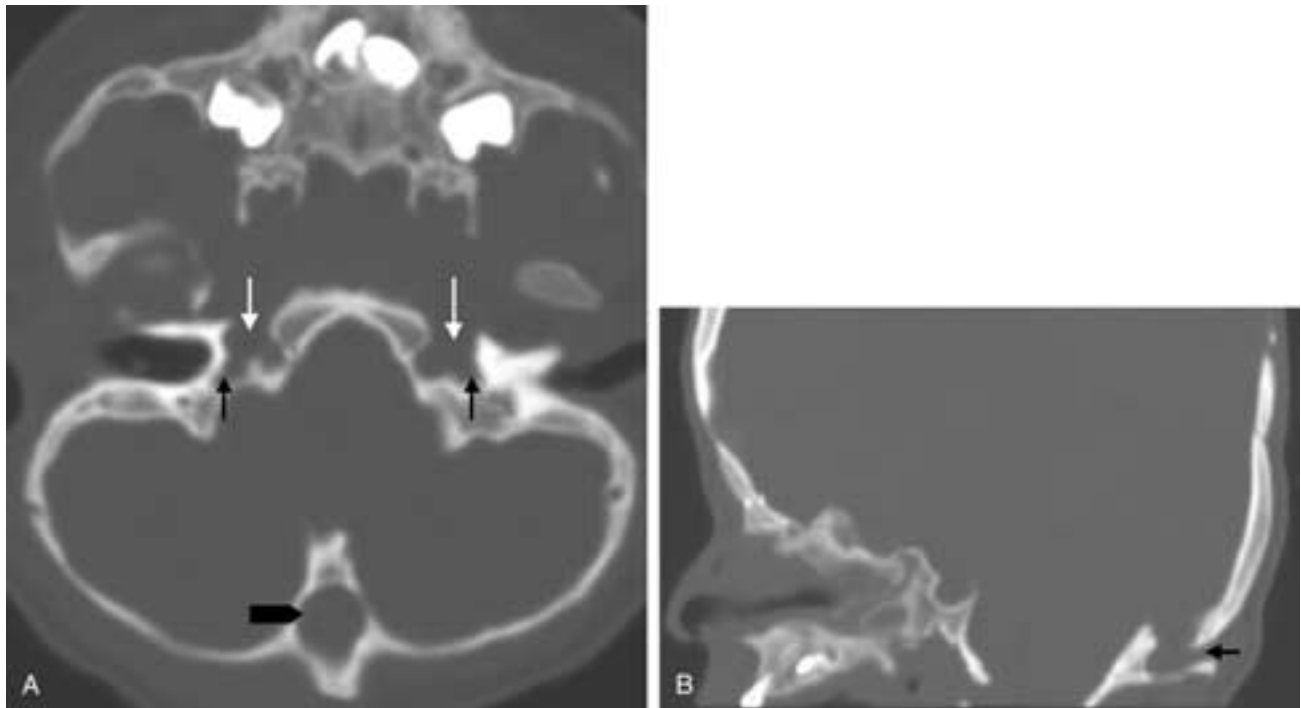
Jugular foramen stenosis. A, Axial CT image showing normal-sized carotid canals bilaterally (white arrows) with marked stenosis of the jugular foramina bilaterally (black arrows) and expansion of the occipital bone in the region of the torcula (black arrowhead), with a defect through which an enlarged emissary vein passes because of severe jugular stenosis. B, Sagittal reconstructed CT image showing a defect (black arrow) in the occipital bone at the site of the confluence of the dural sinuses for the emissary vein to drain.
